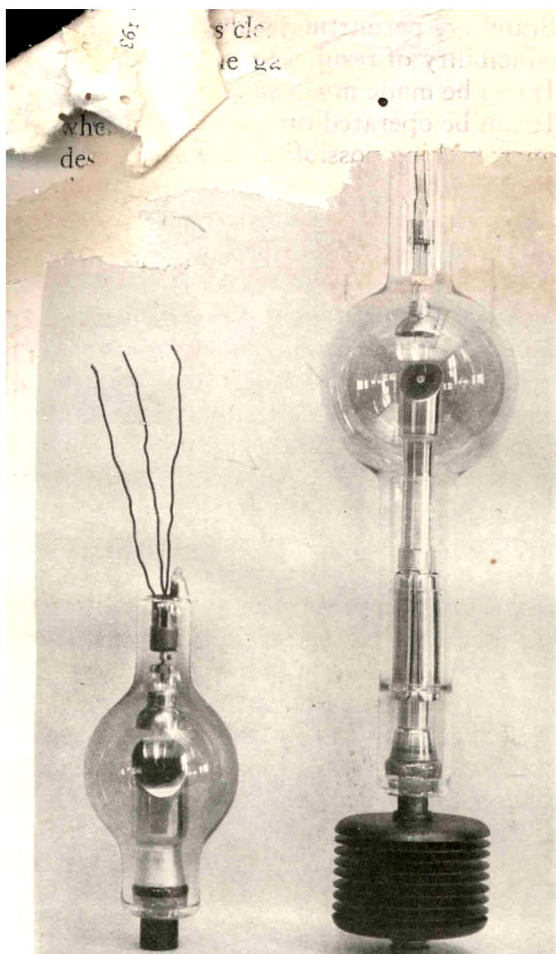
Air-cooled and oil-immersion types of x-ray tube designed for 30 ma. and 85 kv. (peak), the latter capable of continuous operation at this load 8 times as long as the former.
